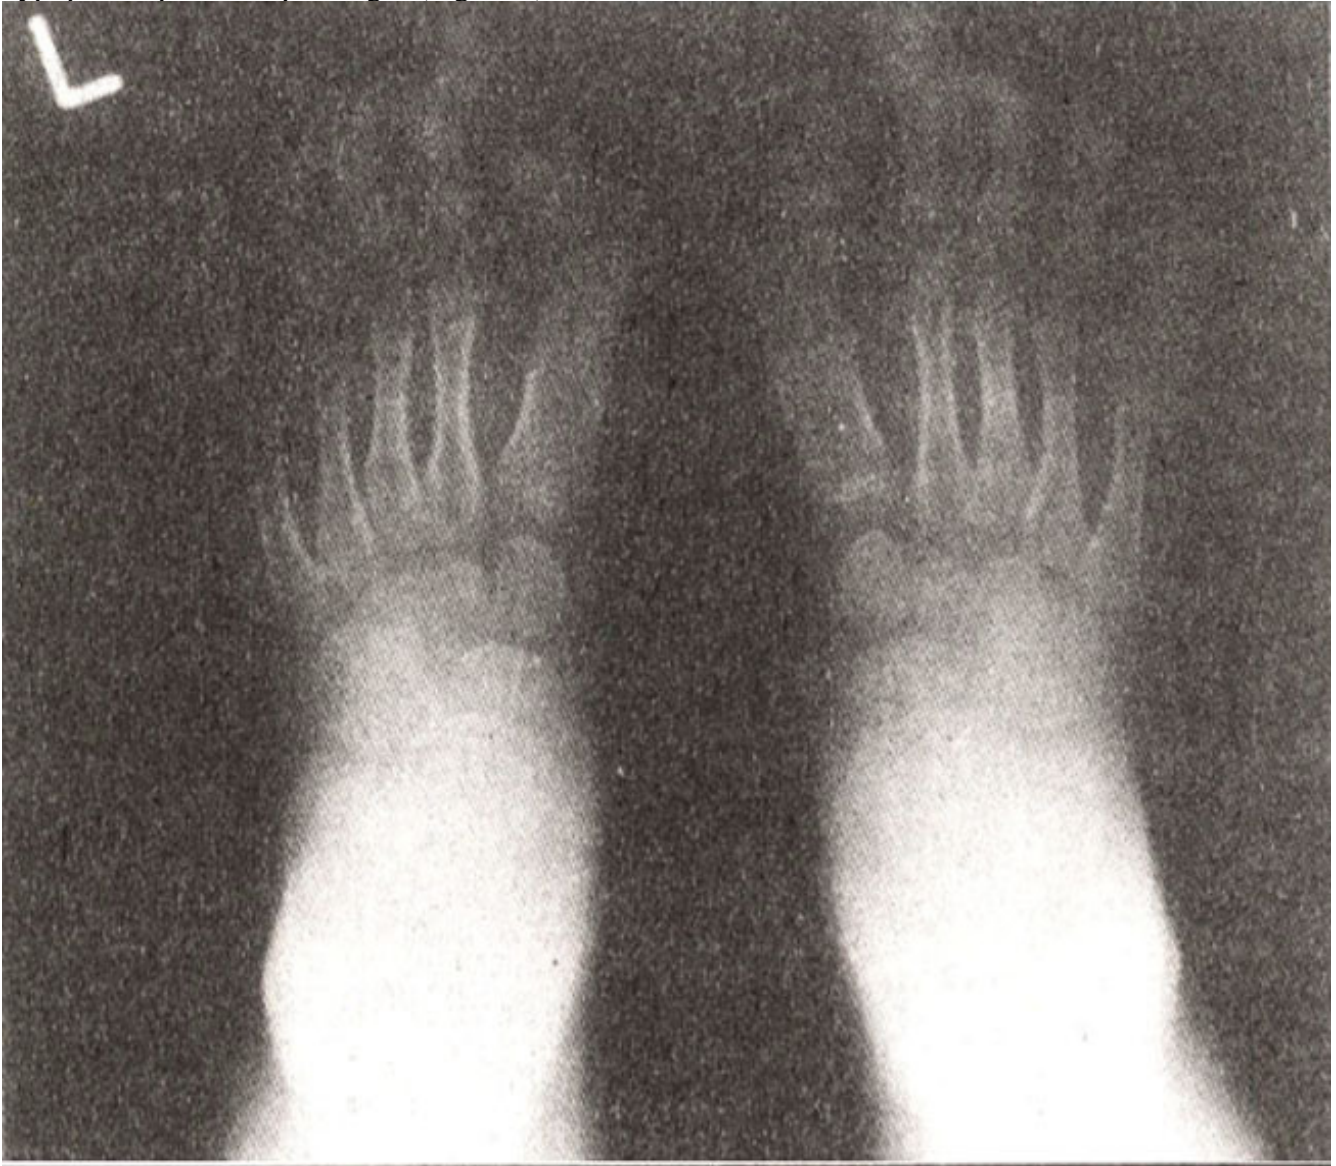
Radiograph of the feet showing hallux valgus deformity with malformed first metatarsals and proximal phalanges.
